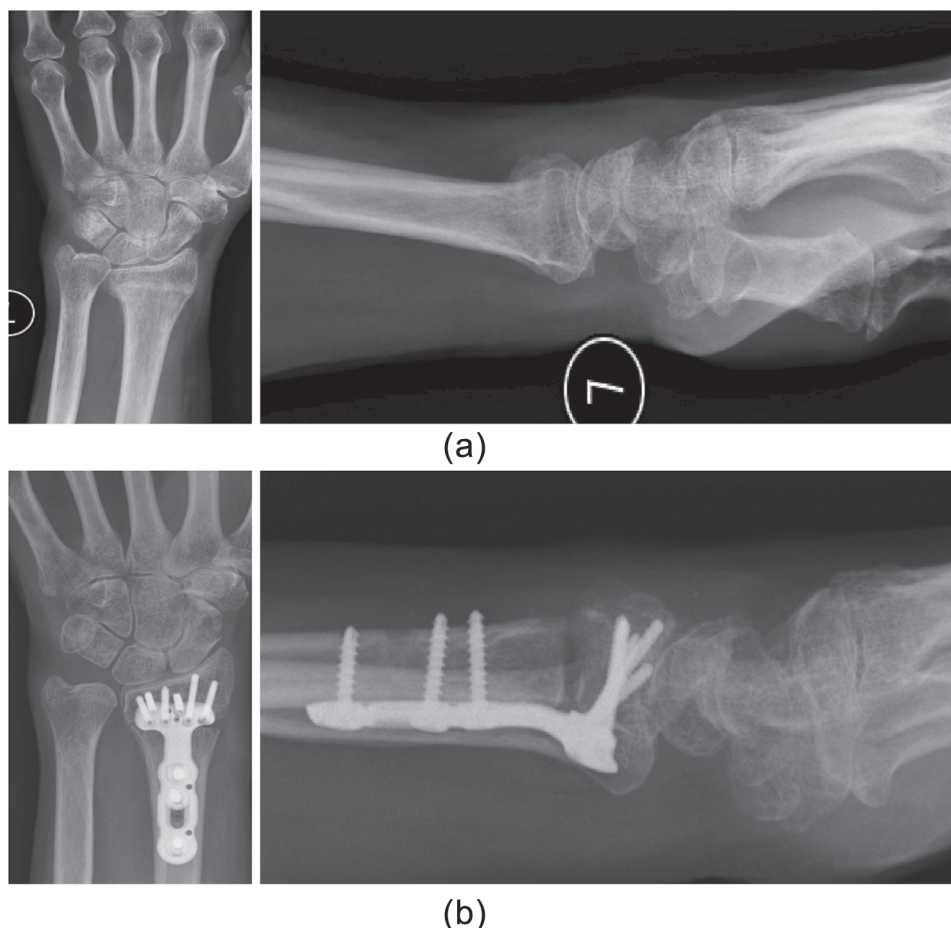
(a) A patient's presentation radiograph. (b) Radiograph 3 months post-operatively.
